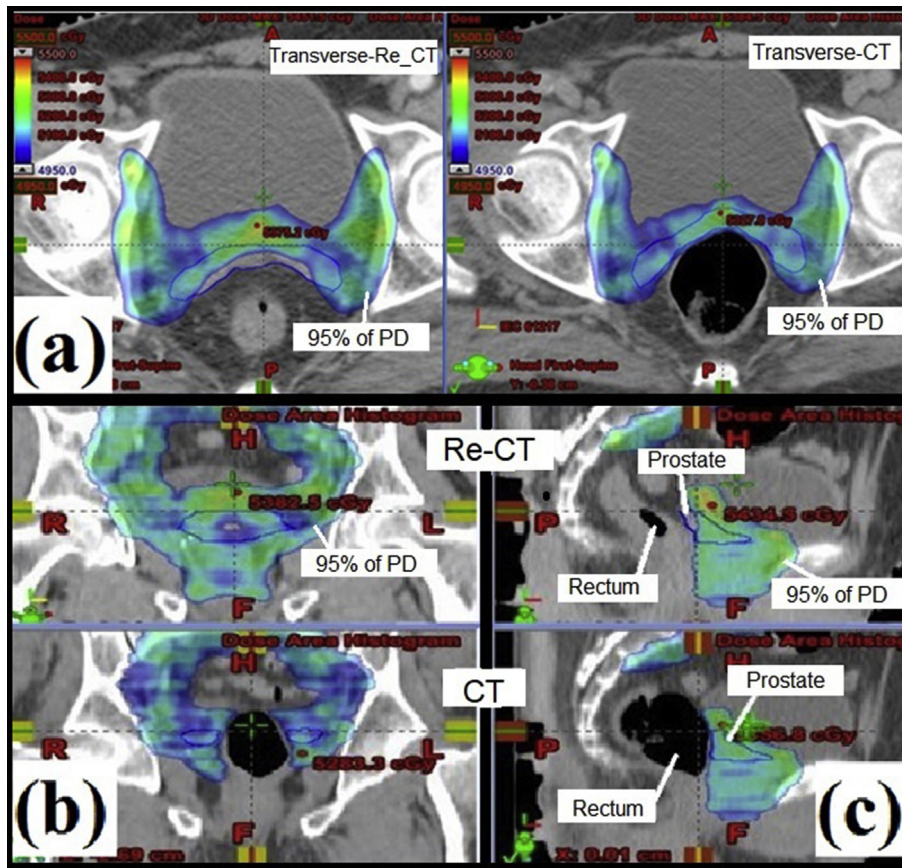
Dose distribution on the hybrid plan on repeat CT images and plan done on day one CT images in (A) transversal, (B) coronal, and (C) sagittal view of repeat CT and CT images of one of the prostate cancer patient.
